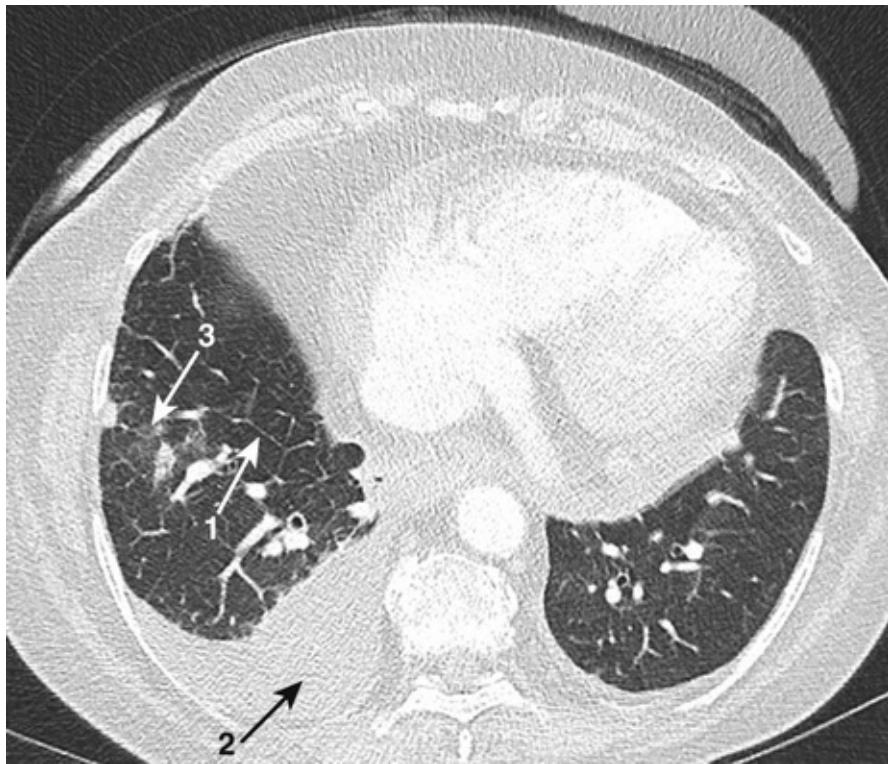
CT lung window settings. Patient presented with increasing breathlessness and history of paroxysmal nocturnal dyspnoea (PND) and orthopnoea. The scan shows typical features of pulmonary oedema. Note the interlobular septae in the right lung base (1), enlarged heart, right pleural effusion (2) and subtle ground glass change (3).
